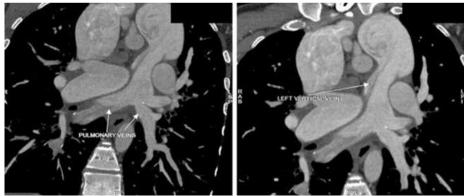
Coronal sections of cardiac CT
